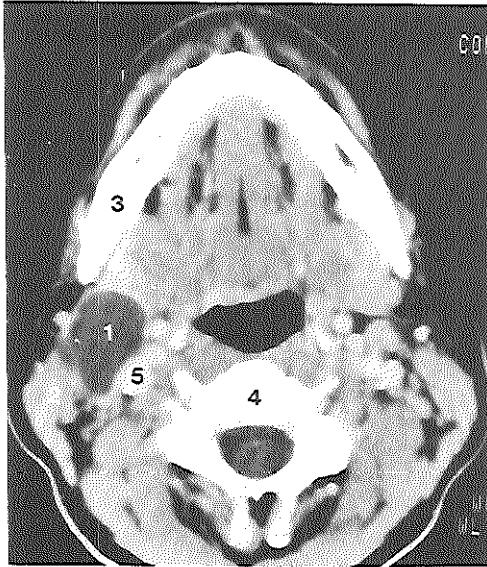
CT section at the level of the second cervical vertebra parallel to the mandible. A well-defined branchiogenic cyst at the anterior border of the sternocleidomastoid muscle is demonstrated.
